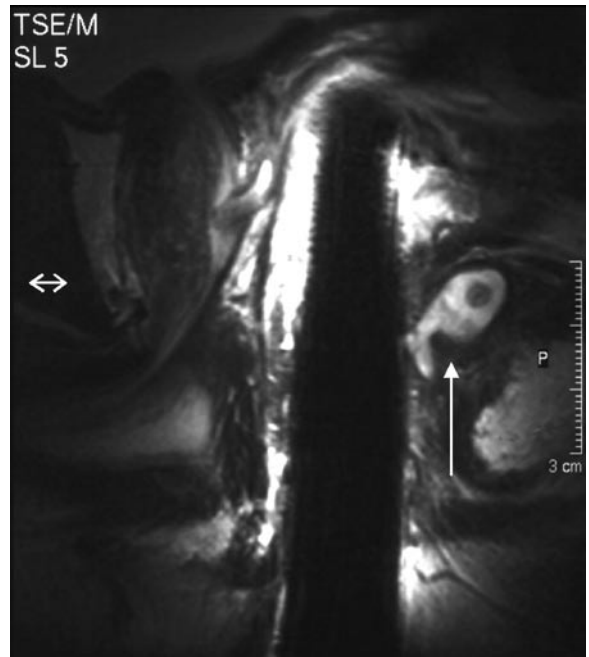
Sagittal T2-weighted turbo spin-echo with endoanal coil reveals an abscess at the level of the puborectal sling in the posterior midline (*arrows*)
